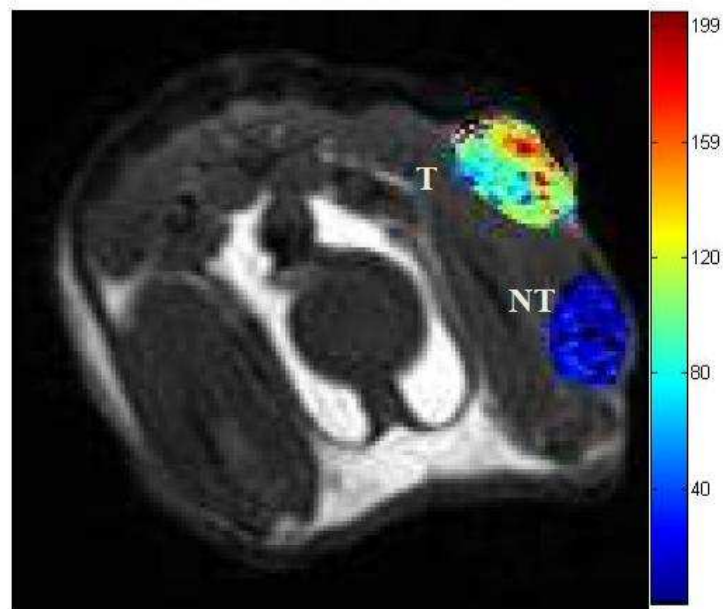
Enhancement image is given. T_1 - weighted MR image at the peak signal enhancement overlaid on the anatomical image. The tumor is denoted with the label T. The label NT denotes the non-tumor region [36].
